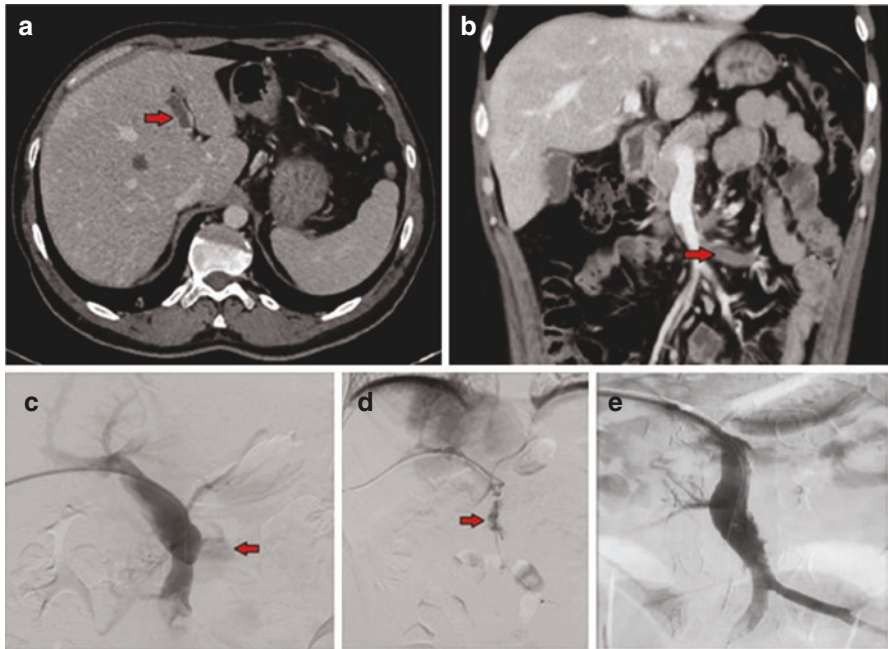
A case with acute PVT successfully treated by catheter directed thrombolysis. (a, b) Abdominal contrast CT revealed that the intrahepatic branches of the portal vein were entirely thrombosed and its extrahepatic segment was nearly totally thrombosed. The thrombus has been extended to the distal branches of SMV (red arrow). (c, d) A 21G needle accompanied by ultrasound was entered into the right portal vein at interventional radiology. A hydrophilic guide wire was placed. A 20 cm long infusion catheter was placed in the SMV for therapeutic purpose. Splenoportography performed at the 20th hour of treatment revealed no complete patency in the SMV and portal vein. (e) On the third day of treatment, splenoportography showed that portal vein lumen was open
